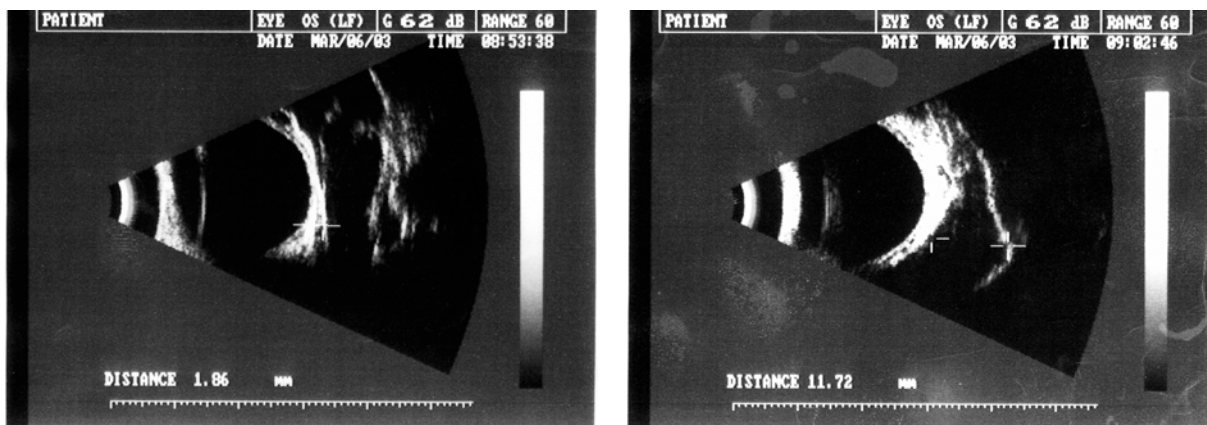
Ultrasound of the left eye showing hypoechoic lesion of the lateral wall of the left orbit with low reflectability and internal septations.
